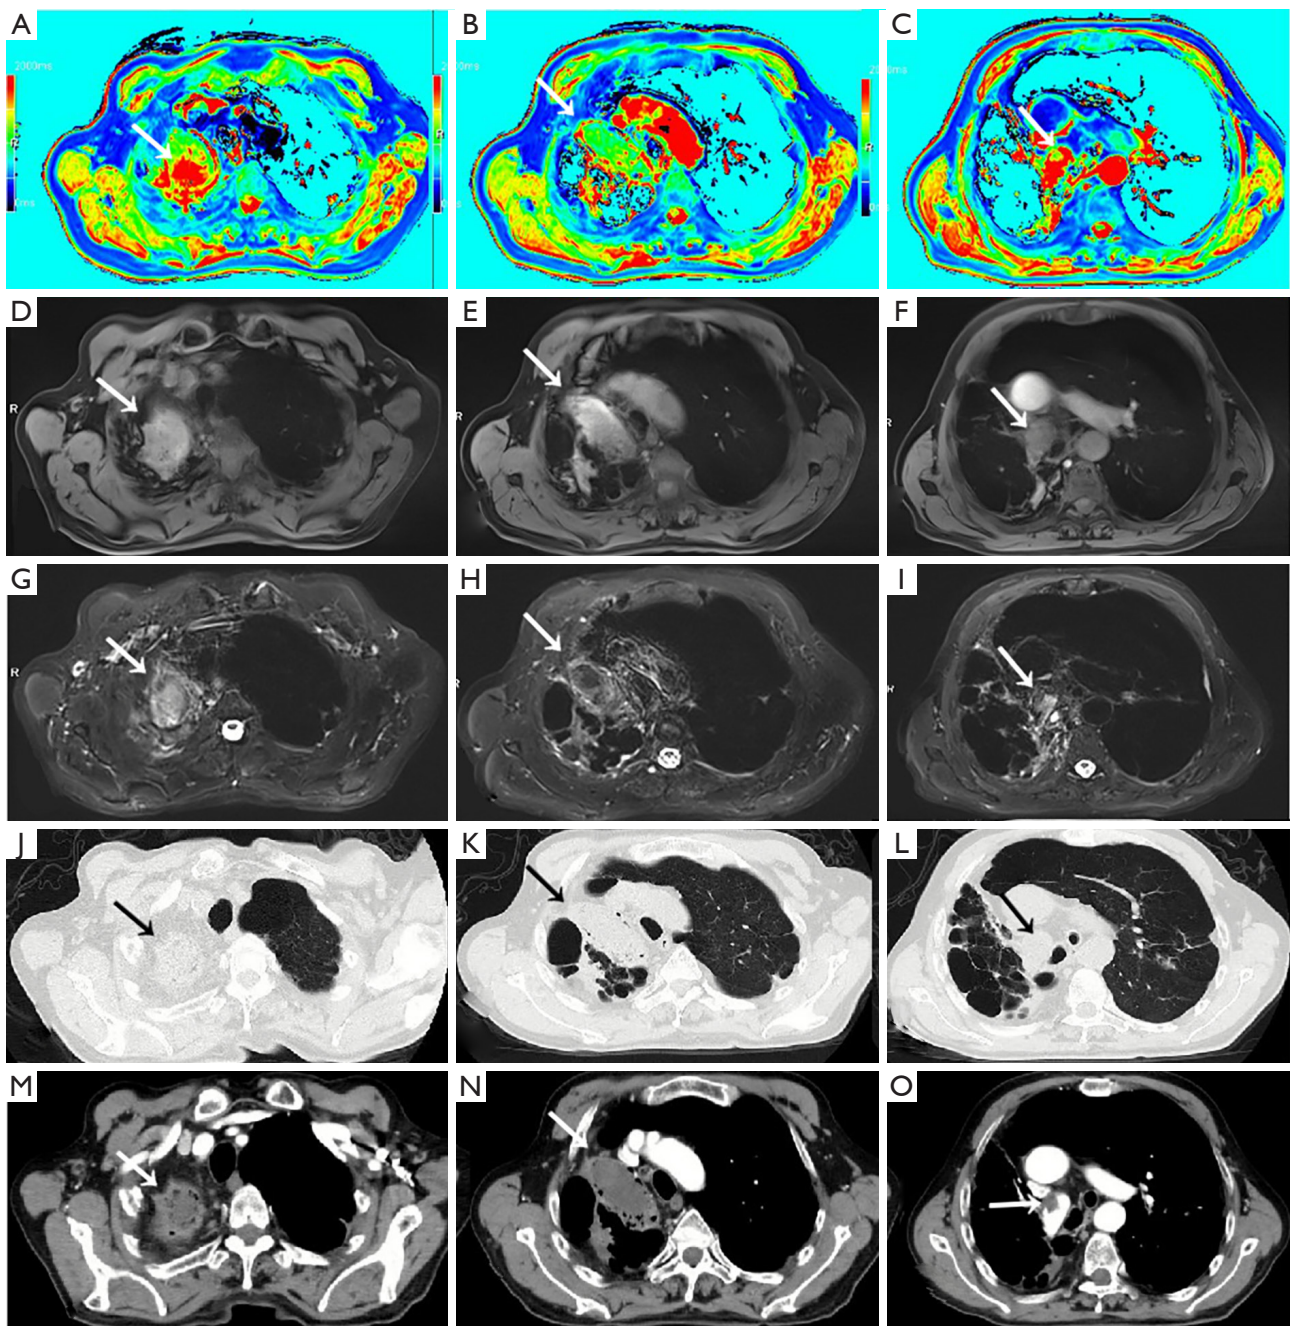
A patient with chronic lung tuberculoma and peripheral active infection. (A,B,C) Native T1-mapping pseudocolor map, (D,E,F) T1-Star VIBE, (G,H,I) T2-fBLADE TSE, (J,K,L) computed tomography (CT; lung window), (M,N,O) CT, mediastinal window, contrast-enhancement. The lesion in the right superior lobe (K/N, '→') was manifested more intensely in T1-starvibe (E, '→') and less intensely in T2-fBLADE TSE (H, '→'). T1-mapping shows the lesion clearly (B, '→'). The peripheral active infection (J/M, '→') manifested less intensely in T1-star VIBE (D, '→') but more intensely in T2-fBLADE (G, '→'). T1-mapping shows the infection clearly, manifested as a red zone (A, '→'). The thrombus in the right pulmonary artery, confirmed by enhanced CT (O, '→') can also be detected by native T1-mapping (C, '→') and T2-fBLADE (I, '→'), but could not be seen in T1-star VIBE (F, '→') and CT (lung window, L, '→'). Due to the difference of the flow velocity and direction in the aorta, the signal intense was nonuniform with the flowing void effect in the ascending aorta. VIBE, volumetric interpolated breath-hold examination; TSE, turbo-spin echo.
